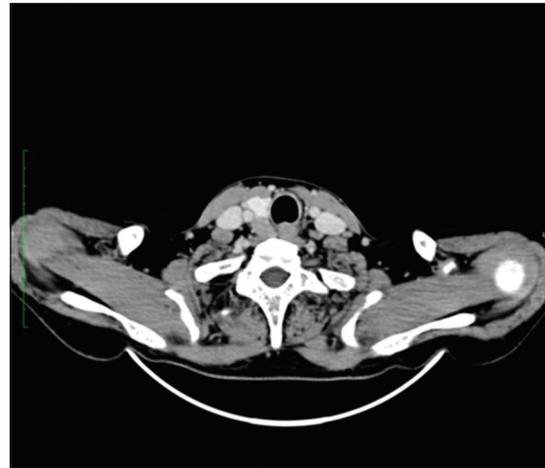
Contrast axial computed tomography scan
